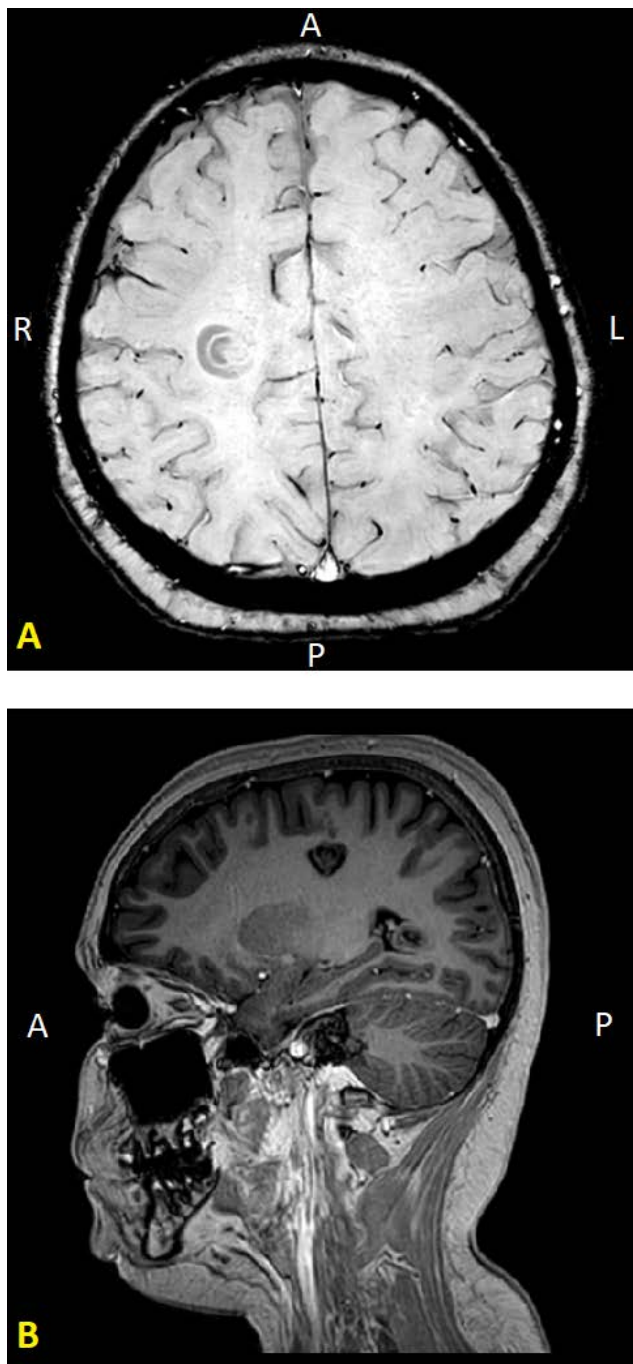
MRI T1 weighted images displaying Baló's lesions characterized by the alternation of concentric myelinated and demyelinated rings in the white matter in (A) axial projection, and (B) sagittal projection
